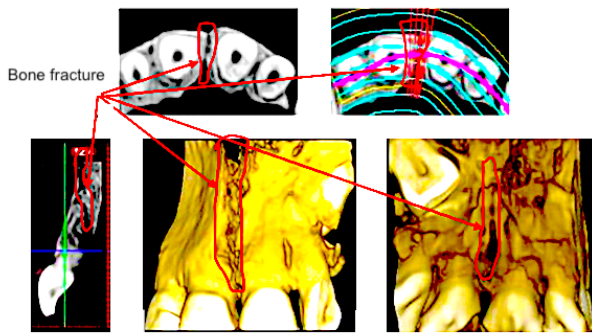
CBCT analysis of fractured mandibular
